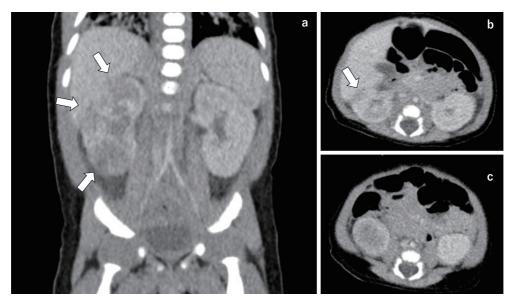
Contrast-enhanced CT image of the abdomen
